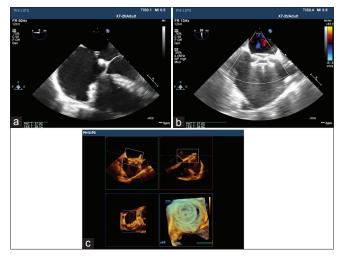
(a) Amplatzer sheath crossing atrial septal defect. (b) Bicaval view showing undeployed Amplatzer device. (c) Three-dimensional transesophageal echocardiographic showing Amplatzer device across atrial septal defect
